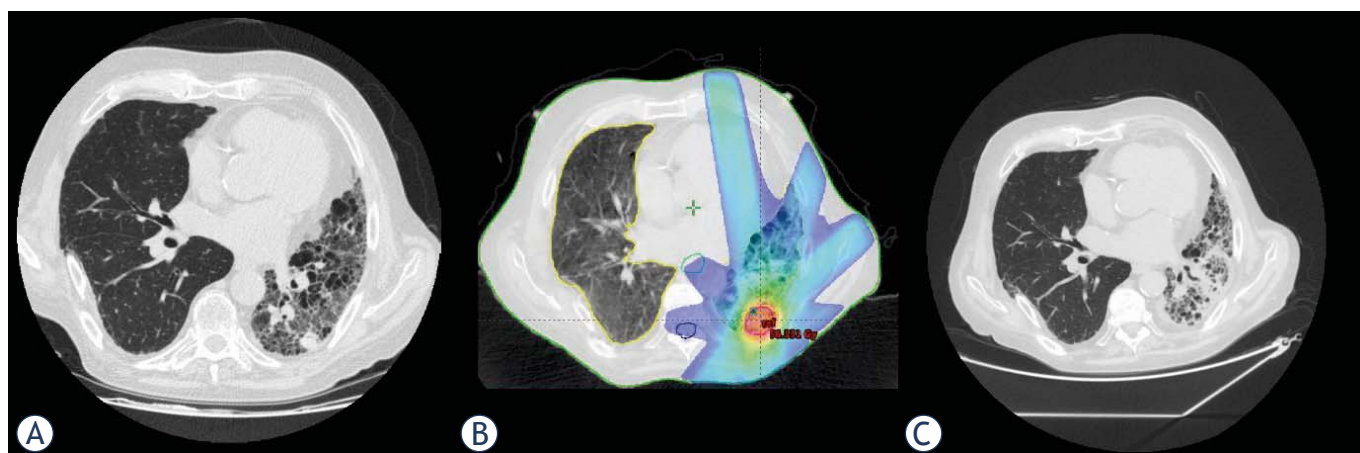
(A) Pretreatment CT demonstrating a nodule was detected in the left lower lobe (B) Radiation field arrangement and dose color wash for SBRT (C) CT 2 months after treatment completion demonstrating a complete disappearance of the target nodule.
